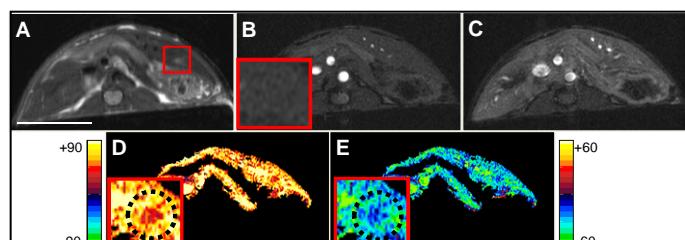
HRI* sensitivity compared to DCE-MRI: (A) Axial T₂W image with suspected CRLM (red square); (B,C) The corresponding T₁W images obtained before (B) and 66 sec after (C) i.v. injection of Gd-DTPA; The suspected lesion was not enhanced with DCE-MRI (B, enlarged square), despite the injection success as the whole liver was enhanced (C). In the corresponding *HRI* maps (D- ΔS_O_2 map, E- ΔS_{CO_2} map), the suspected CRLM were clearly highlighted (D,E circles). Bar=1 cm in A and applies for all images;
